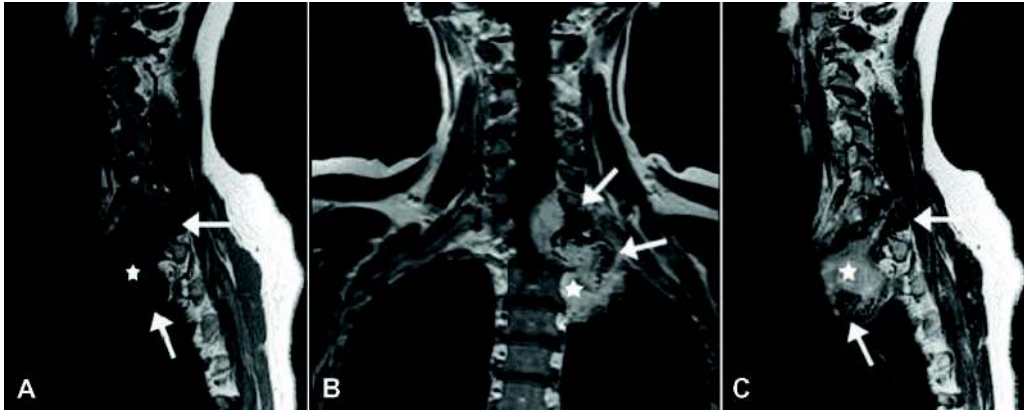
Ossifying fibromyoid tumor of soft parts at the base of the neck. (A) Sagittal T1-weighted, (B) coronal T1-weighted post-contrast and (C) sagittal T2-weighted MR images reveal the soft tissue mass (*) with diffuse contrast enhancement and intermediate signal intensity. Local area of prominent low signal intensity represents peripheral calcification (arrows).
